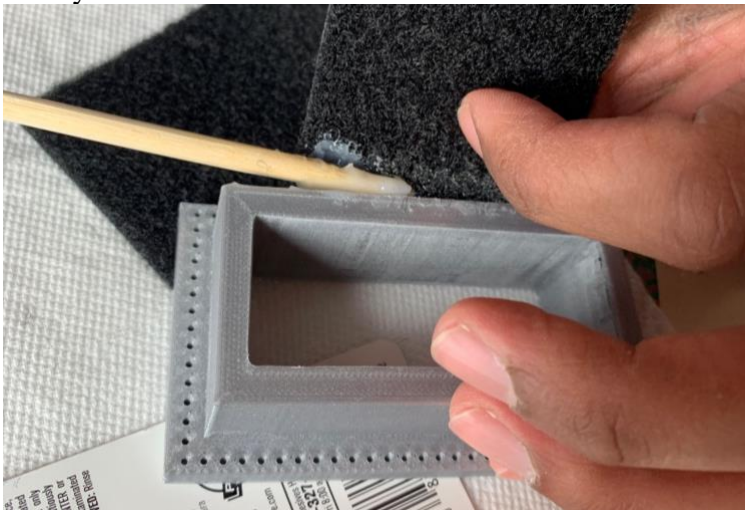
Prototype Presented in Final Prototype Presentation—A second attachment ring was added to the design in order to allow ultrasounds to be performed on different areas of the shoulder.
